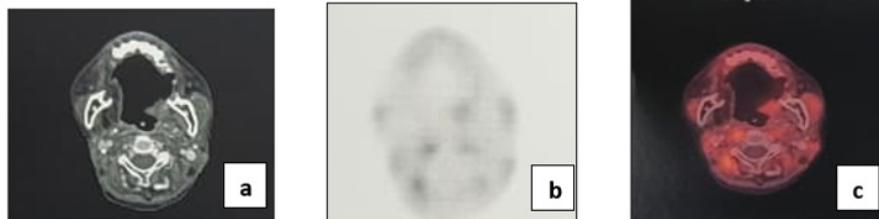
(a), (b) and (c): PET-CT scan taken after 7 months showing mild focal area of increased metabolic activity noted along the remnant tongue extending in to the left side appears to be physiologic uptake.
